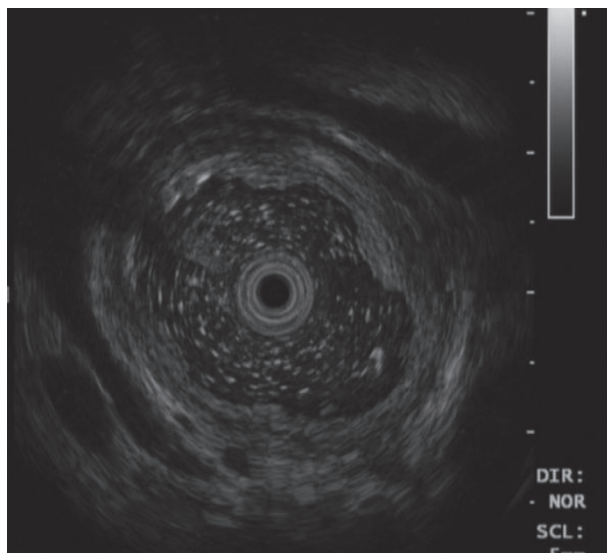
The lack of mucosa and submucosa muscular layer of the lesions via ultrasound endoscopy.
